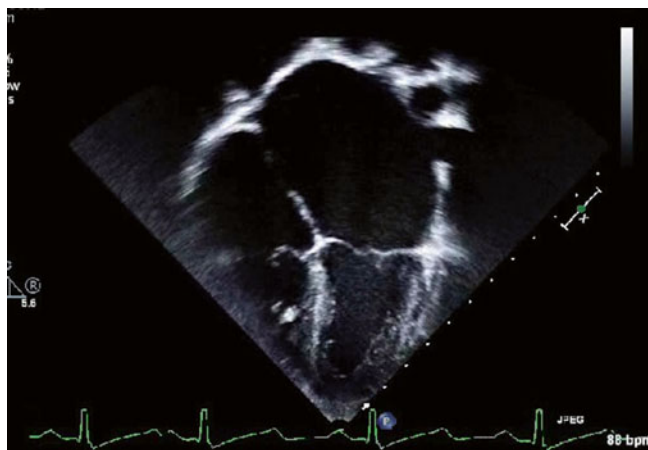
Representative echocardiogram in RCM. The classic finding by echocardiogram is large atria and normal ventricular size
